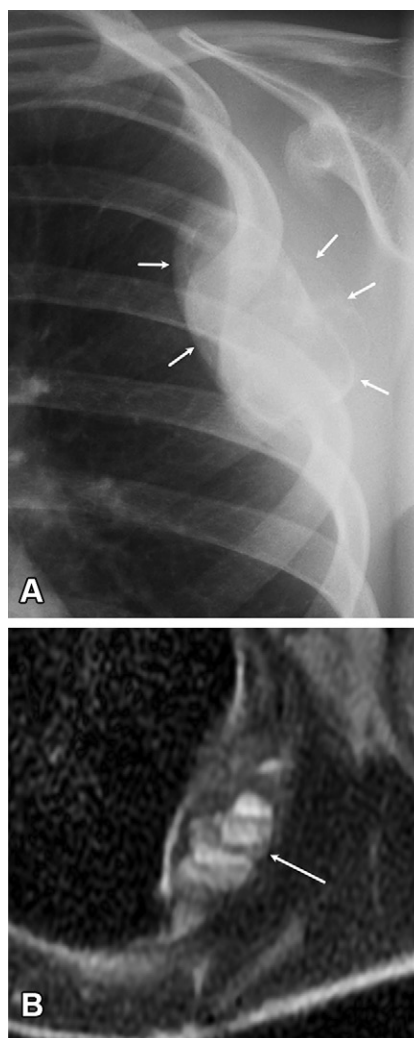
ABC in a 9-year-old boy. (A) Frontal chest radiograph shows a large expansile osteolytic lesion with a sharply defined multilobulated border (arrows) involving the left fourth rib. The outer cortex is extremely thinned. (B) Axial T2-weighted image shows multilocular cystic lesions (arrow) with internal fluid-fluid levels without solid components.
